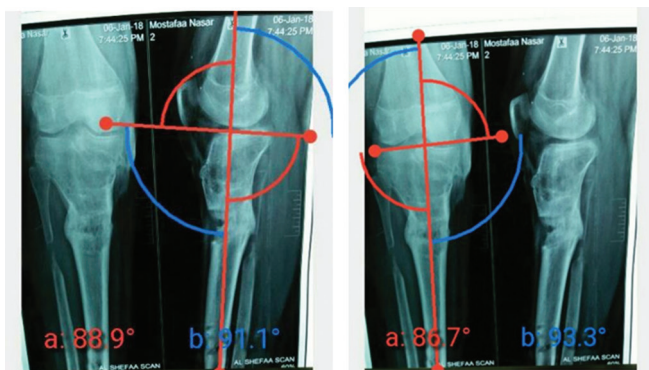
Postoperative radiography with different angles.
